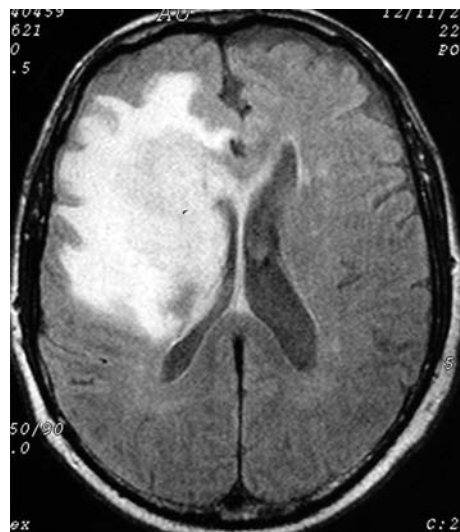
First head MRI disclosed a gadolinium-enhancing right frontal mass lesion adjacent to the frontal horn of right lateral ventricle. Coronal T1 sequence showed a ring lesion involving right caudate nucleus head. This FLAIR sequence shows marked vasogenic edema. Anatomicopathological studies confirmed glioblastoma.
